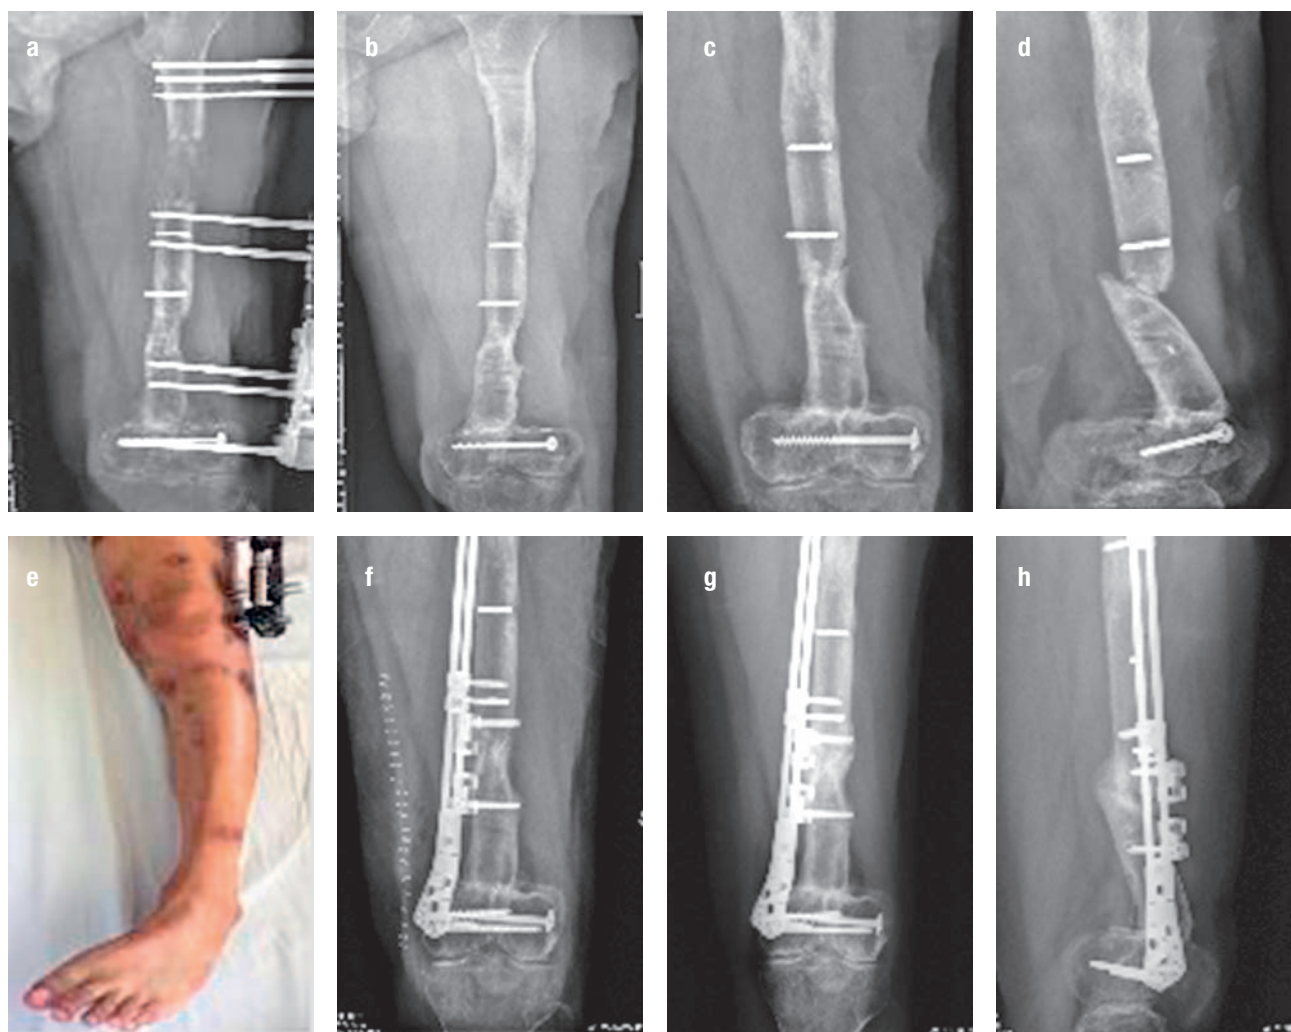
41-year-old male patient suffered from recurrent fracture 2 week after removal of external fixator after multi-segment bone transport of left femur: (a) the femoral anteroposterior X-ray after removal of femoral bone transport; (b) the femoral anteroposterior X-ray after removal of external fixator; (c) the femoral anteroposterior local X-ray after removal of external fixator; (d) the femoral lateral X-ray after fracture; (e) the femoral lateral thigh skin difference; (f) the femoral anteroposterior X-ray; (g) the 4 months after operation; (h) the 4 months after operation, femoral lateral X-ray.
